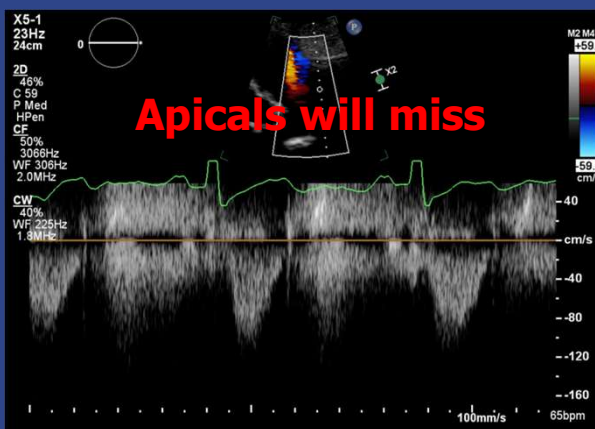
Apical CW Doppler across intra-op TAVR, from author's clinical collection, di-identified (M.Trump, 2025)
